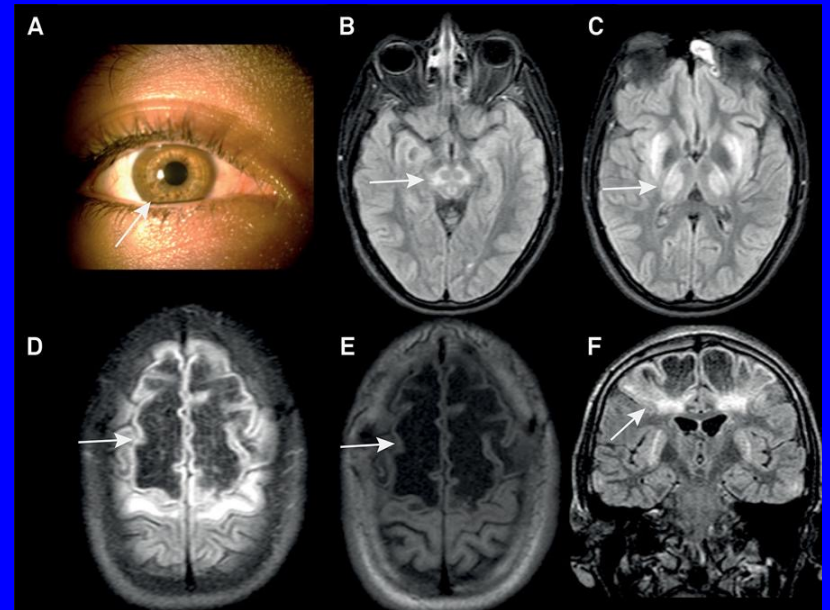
Kayser-Fleischer ring (arrow). B and C: Axial FLAIR-weighted brain MRI shows a giant Panda sign and hyperintense signs in the basal ganglia. D, E and F: marked bilateral frontal leukoencephalopathy with cystic lesions.
